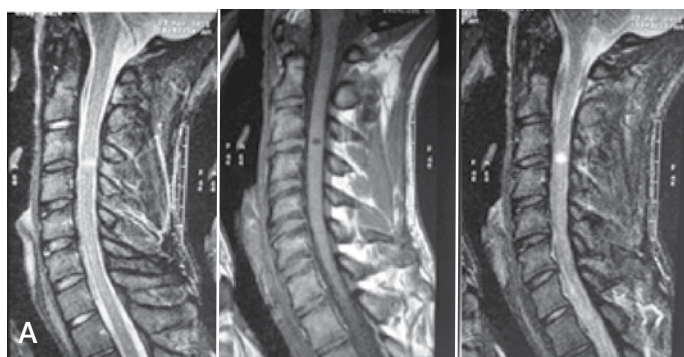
Patient aged 20 years, driver wearing a seatbelt (A) sagittal MRI sections in T2, T1 and STIR on admission, showing an intramedullary lesion (hematoma). (B) Sagittal sections in T2 and T2 6 months after conservative treatment.
